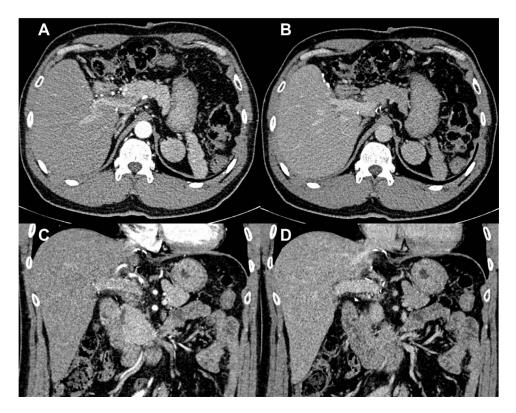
Contrast-enhanced CT scan performed 1.5 years postsurgery confirmed the absence of residual disease after left hepatectomy. Axial (A, B) and coronal (C, D) reconstructions depicted the arterial phase (A, C) and portal venous phase (B, D).
